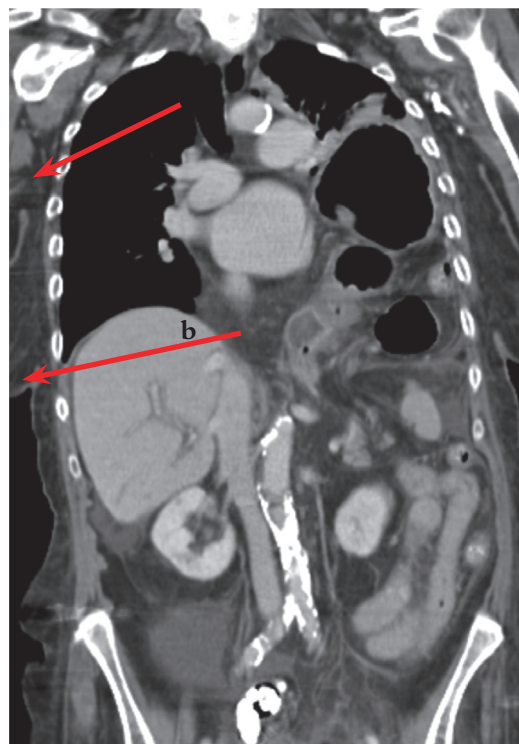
Coronal CT of lower thorax and abdomen of patient described in case 1 at the time of her previous presentation with bowel obstruction secondary to diverticular stricture. The gastric fundus (a) is in the chest cavity and the diaphragmatic hiatus (b) is widened.
